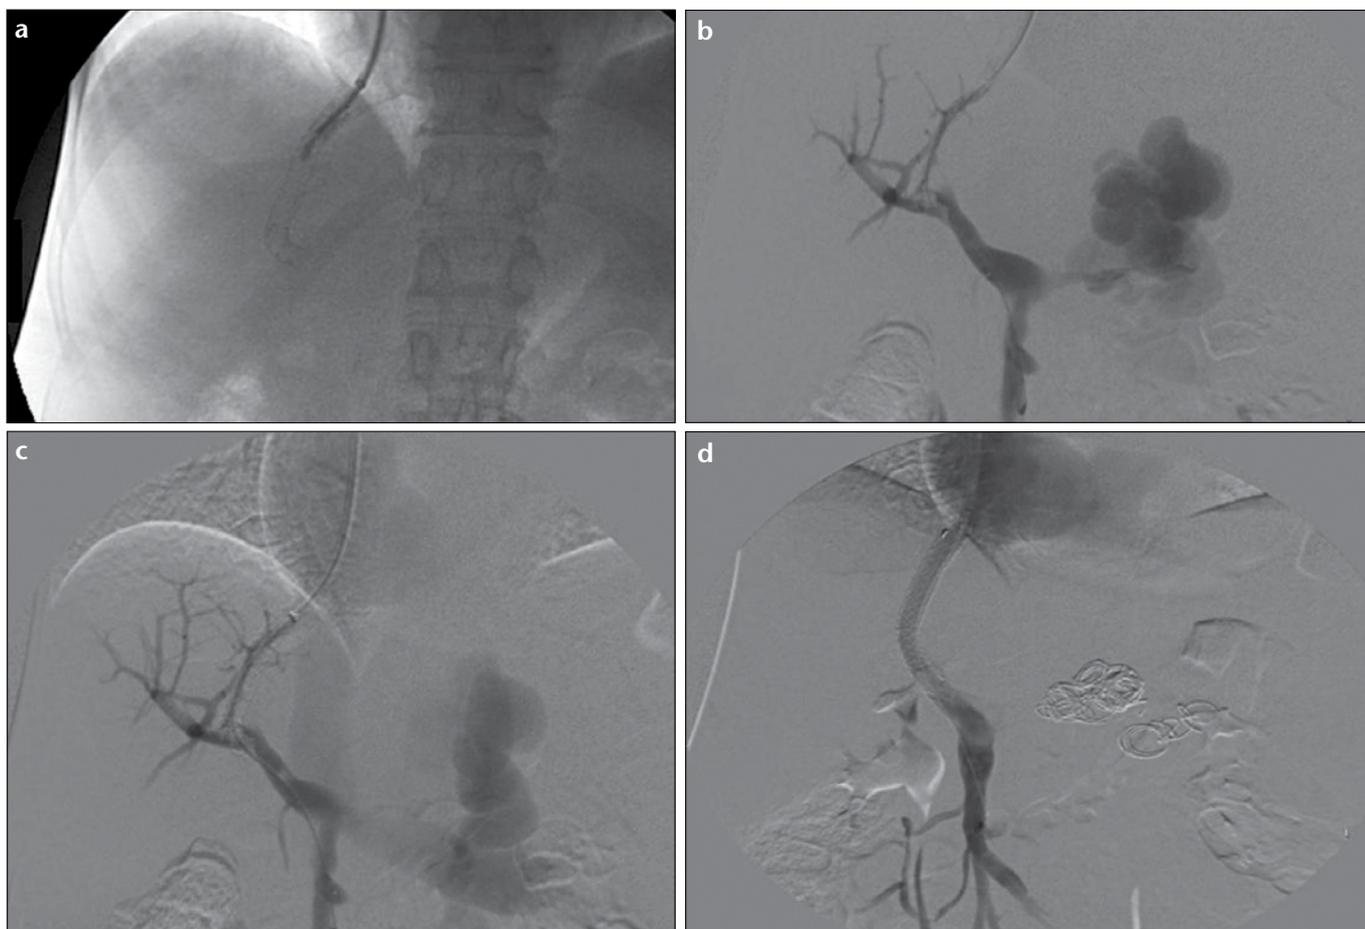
a–d. A 63-year-old patient who underwent covered TIPS two months earlier for recurrent variceal bleeding that was not responsive to endoscopic therapy. Doppler US showed TIPS occlusion and standard transvenous catheterization of the occluded stent was failed. The fluoroscopic image (a) shows that the Colapinto needle was advanced into the occluded stent under fluoroscopic control. A 5F angiographic catheter (b) was advanced over a hydrophilic guidewire into the superior mesenteric vein. The portography confirmed stent occlusion with filling of large perisplenic varices. Delayed phase of the portography (c) shows a patent spontaneous splenorenal shunt. The decreased flow through the TIPS due to the presence of the competitive spontaneous shunt was considered as a possible cause of stent occlusion. The portal pressure gradient was 7 mmHg. The low portal pressure gradient was due to the large patent splenorenal shunt. The final portography performed after perisplenic variceal coils embolization and new coaxial covered stent placement (d) shows good flow through the stent without filling of perisplenic varices. The final portal pressure gradient was 3 mmHg.
